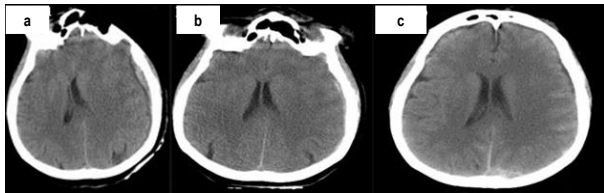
a.Initial CT revealed ASDH with low density areas and marked midline shift. b. First control CT taken approximately one and a half hours after admission showed spontaneous obvious reduction of ASDH and midline shift. c. Second control CT taken approximately 15 hours after admission showed no midline shift and a total resolution of ASDH.
